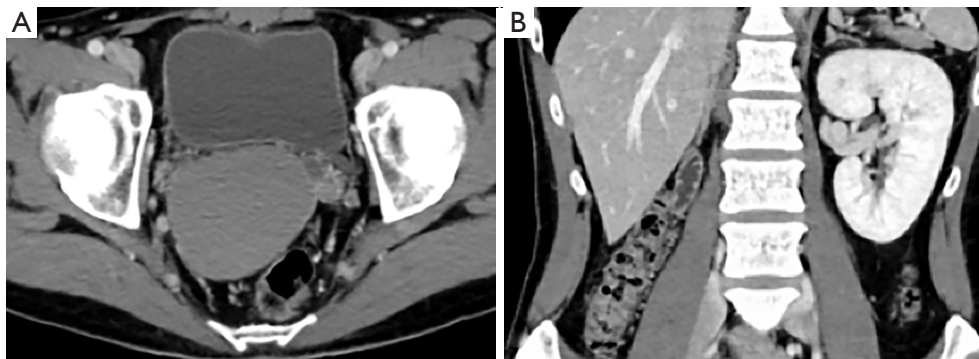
Enhanced computed tomography scanning revealed slightly high density mass without enhancement (A) and defect in the right kidney (B).
